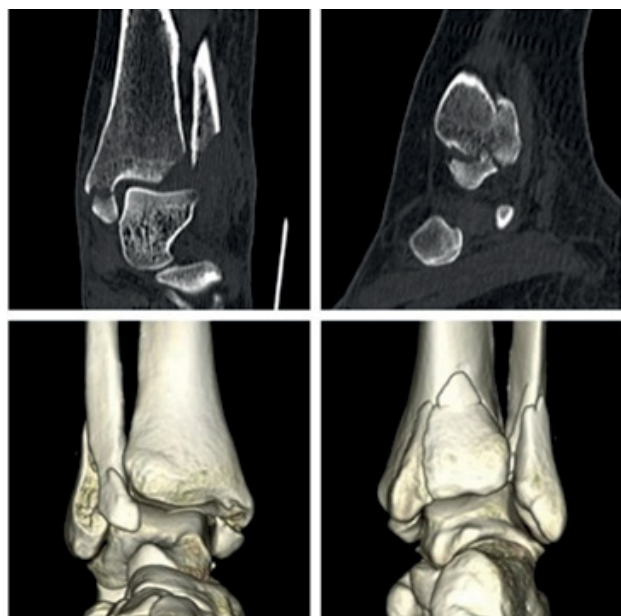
A 35-year-old woman with left ankle fresh fracture (AO-44-B3, Lauge-Hansen Supination eversion rotation fracture type IV) (medial malleolar fracture of Herscovici type B). Preoperative CT, showing left ankle fracture (Herscovici type B).
